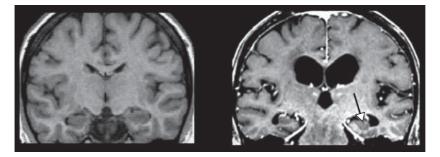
Structural magnetic resonance images in a control and an early AD patient. Coronal slices show a reduction of hippocampal volume in AD (arrow).
